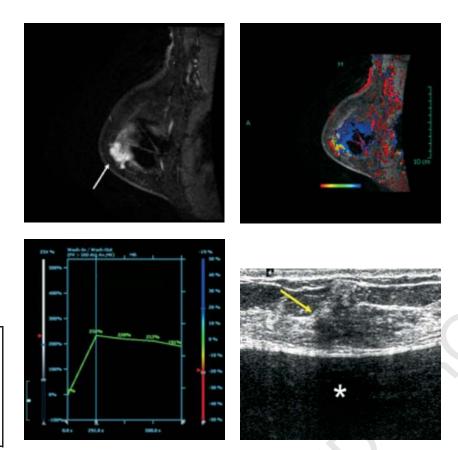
Breast MRI examination on a 58-year-old woman with implants. Sagittal DCE-MRI shows an enhancing mass (arrow) in the 9:00 region of the right breast (upper left panel). Sagittal CAD color image shows marked enhancement (cursor; upper right panel). Enhancement curve shows rapid wash-in and washout kinetics (lower left panel). Ultrasound performed after the MRI shows an irregular, hypoechoic mass (arrow) anterior to the implant (\*) (lower right panel). Ultrasound-guided core biopsy was performed, revealing invasive lobular carcinoma. Abbreviations: CAD, computer-aided diagnosis; DCE-MRI, dynamic contrast-enhanced magnetic resonance imaging; MRI, magnetic resonance imaging.
